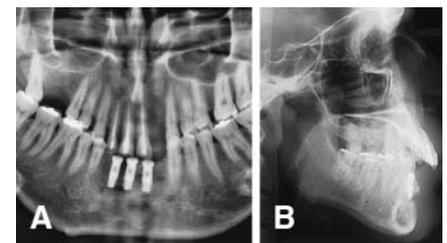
Orthopantomography (A) and maxillary X-ray telegraph (B) of the dentulous patient after implant insertion. A radiopaque spot, due to the last biopsy performed, is visible between the first and the second implant (from the left to the right of picture A).
